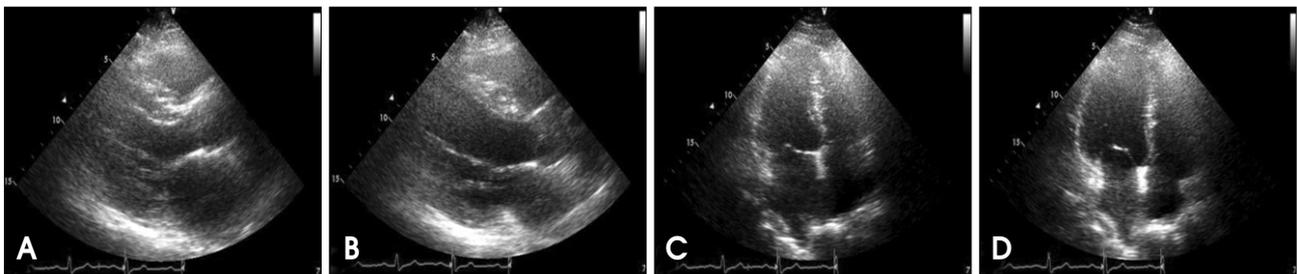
Two-dimensional echocardiography on 3 months later. Parasternal long axis view (A: end-systolic, B: end-diastolic) and Apical 4 chamber view (C: end-systolic, D: end-diastolic) show normalized left ventricular internal diameter compared with that on admission (Fig. 4).
